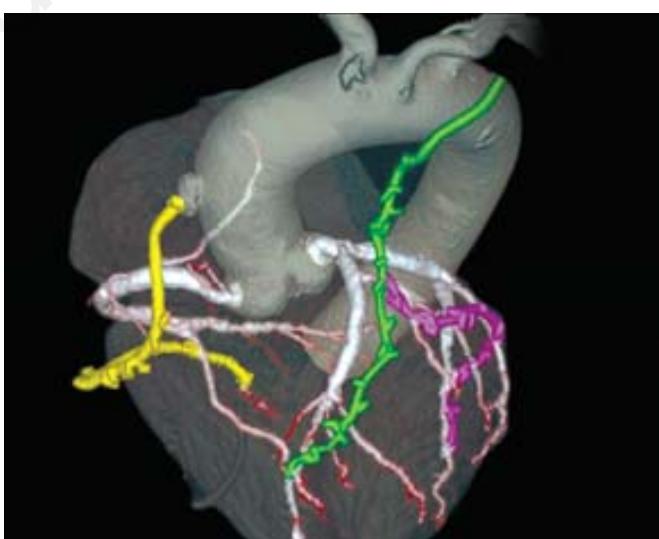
First 1-year follow-up computed tomography angiogram of a patient with 12 grafts.
